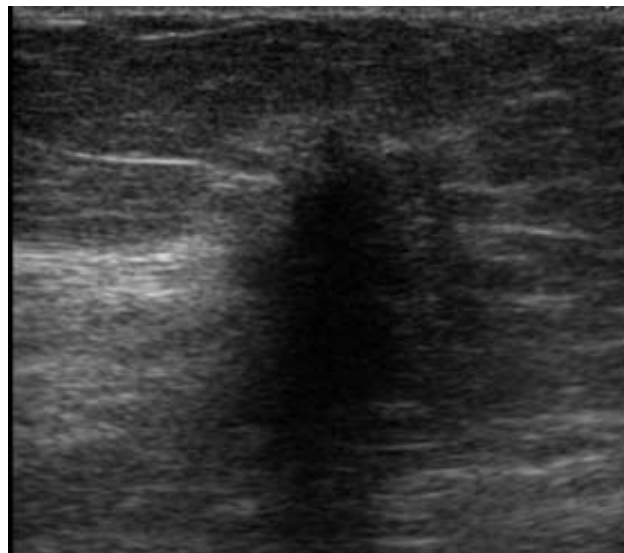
Ultrasound image of breast masses categorized as Breast Imaging Reporting and Data System (BI-RADS) 5.
